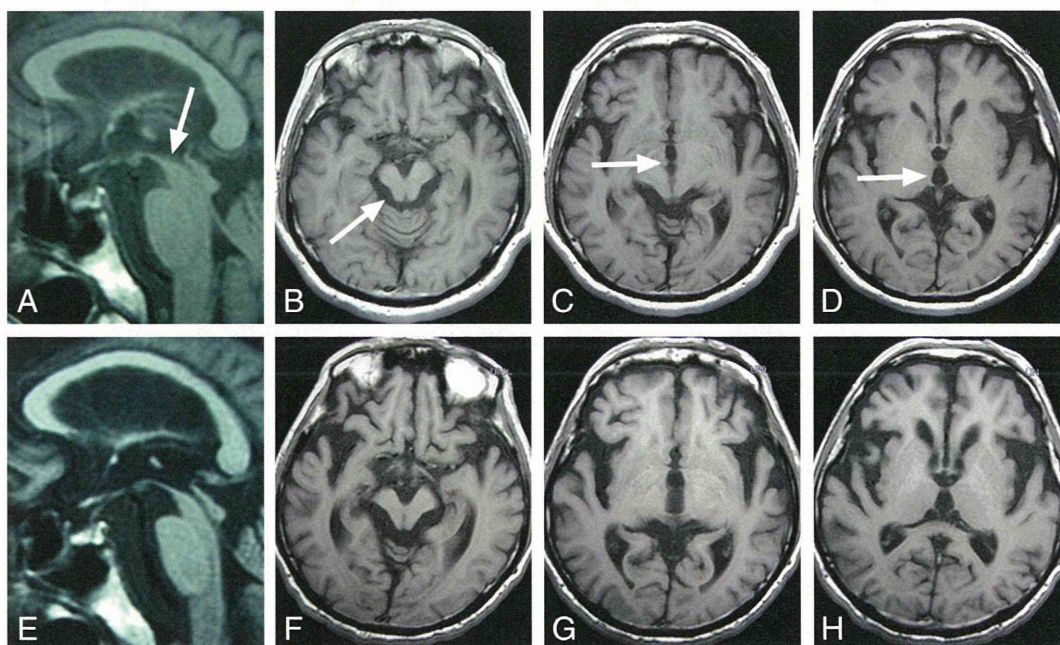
On a midline sagittal T1-weighted image of brain MRI at age 64 (A), the superior surface of the midbrain showed a flat aspect (arrow), suggesting the presence of slight atrophy of the rostral midbrain tegmentum. On axial T1-weighted images at age 64 (B–D), there was no apparent atrophy of the midbrain tegmentum (B, arrow) or enlargement of the third ventricle (C, D, arrow). On midline sagittal (E) and axial (F–H) T1-weighted images at age 68, there was evident atrophy of the midbrain tegmentum (E, F) and slight enlargement of the third ventricle (G, H).
